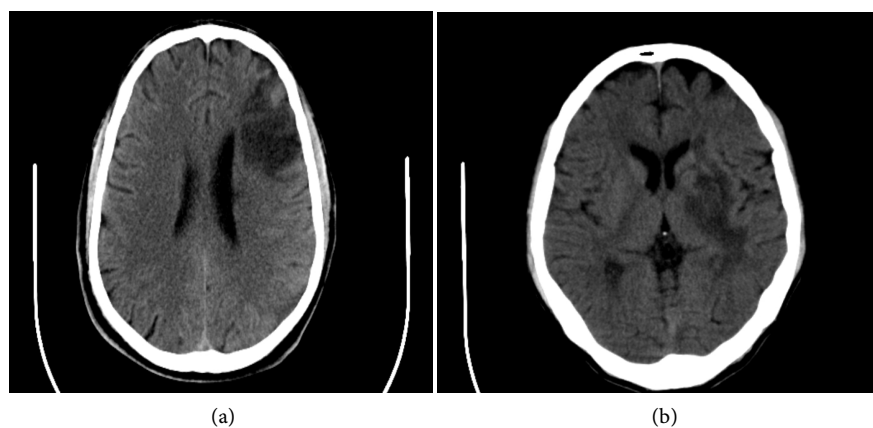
CT findings. (a) LT Frontal infarction 3 \times 3.6 cm; (b) LT Basal ganglia infarction 3 \times 2.4 cm.
